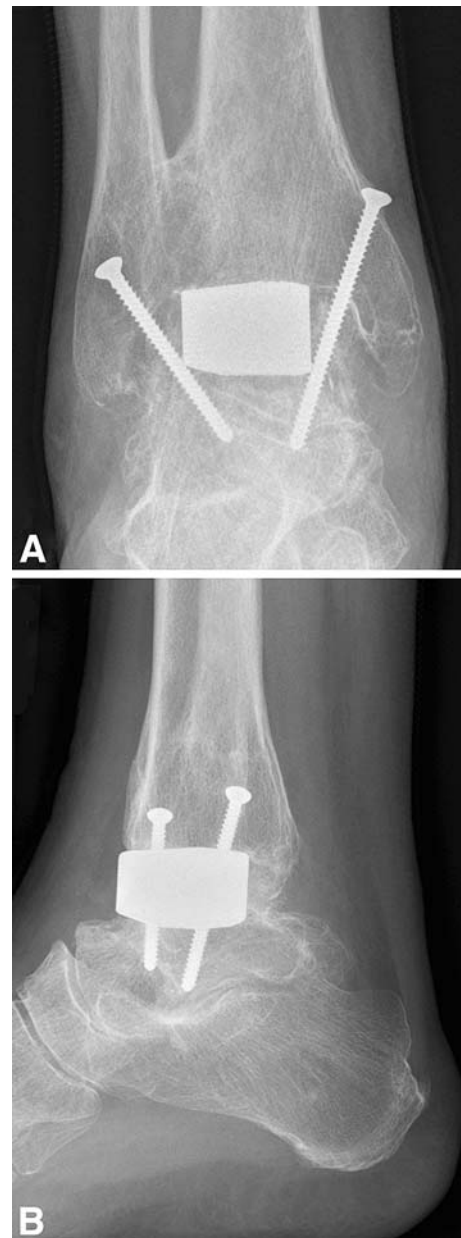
B (A) Anteroposterior and (B) lateral radiographs show an ankle fusion with a tantalum spinal fusion device after failed total ankle arthroplasty. The 14-mm high tantalum block bridges a large bony defect between the tibia and talus. The radiographs show signs of bony incorporation of the tantalum and fusion of the ankle.
